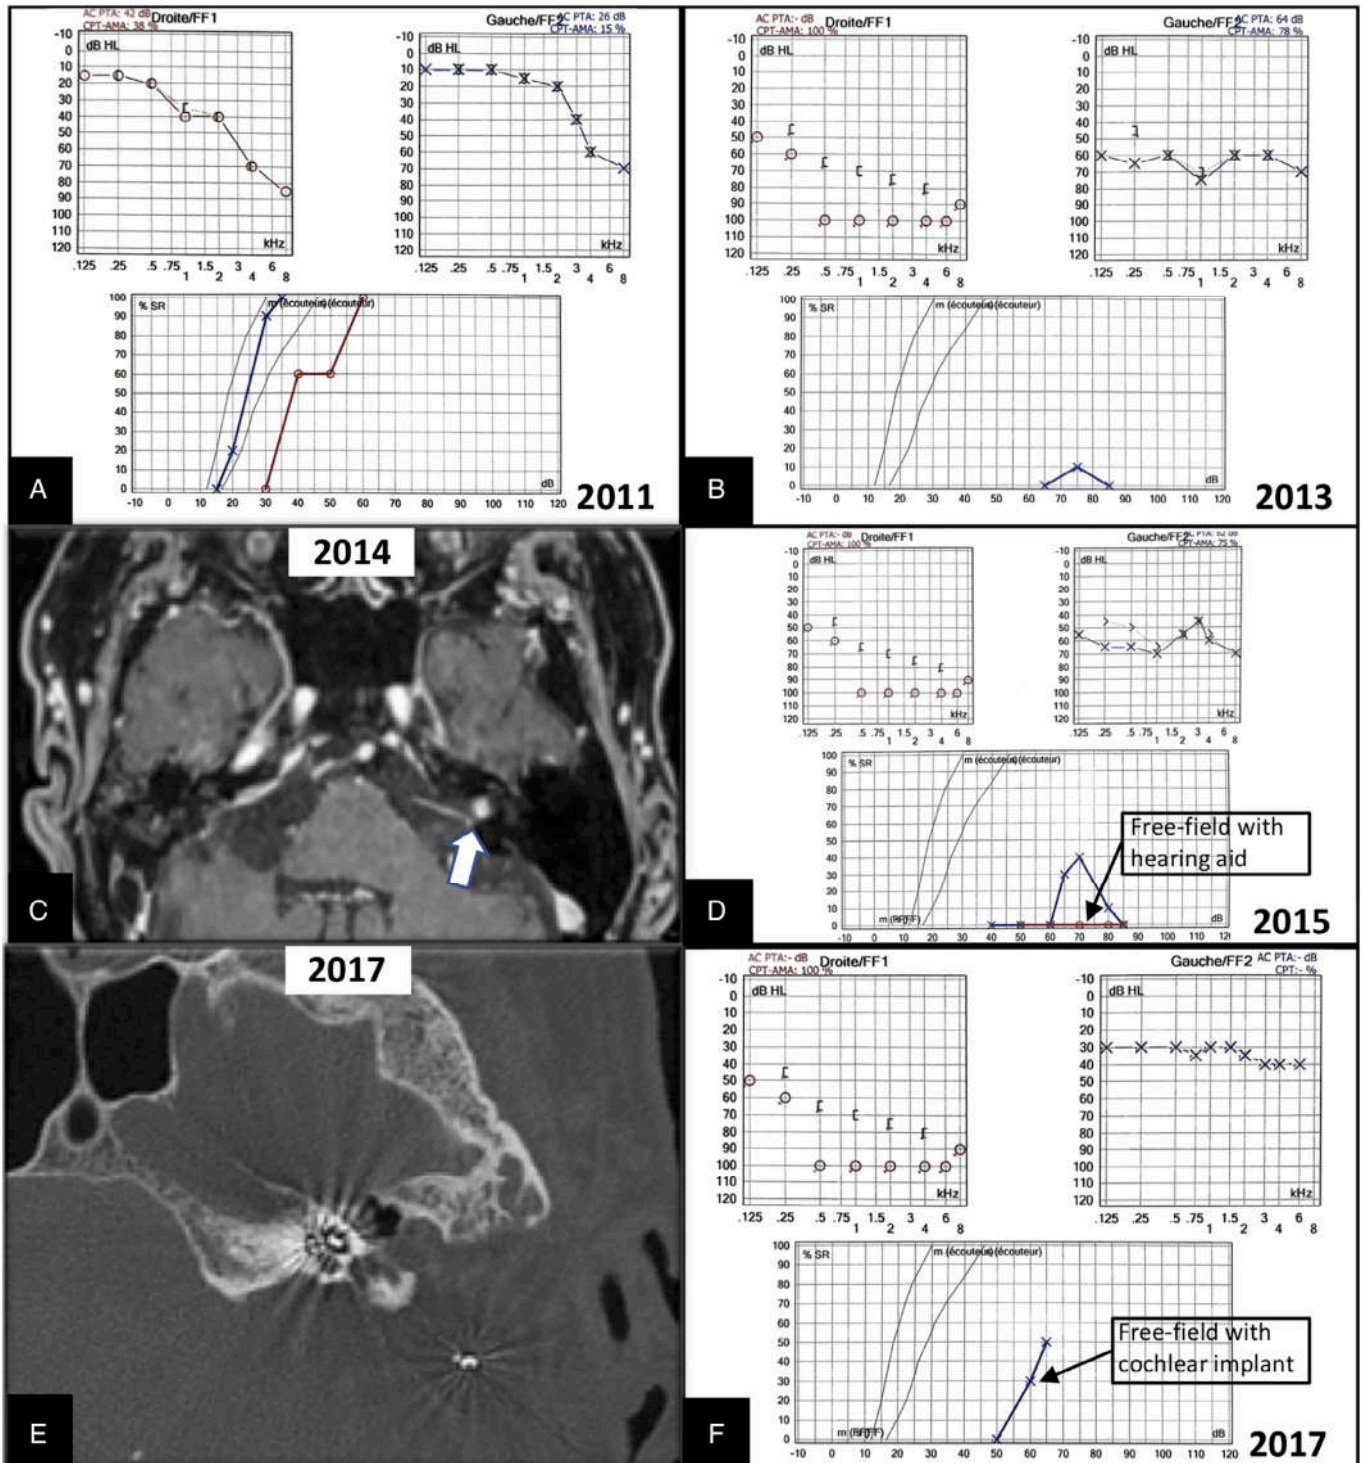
Case 4. (A) Audiogram showing the hearing loss before right vestibular schwannoma removal through a translabyrinthine approach. (B–D) Audiograms showing sudden left sensorineural hearing loss (SNHL) 2 years later (B) with partial recovery after intravenous steroid therapy and no benefit of hearing aid (D). (C) Postoperative axial T1-weighted gadolinium-enhanced magnetic resonance imaging showing evolution of a contralateral left side vestibular schwannoma (VS) (white arrow) revealed by sudden SNHL. (E) Postoperative computed tomography (CT) scan of the patient after removal of the left-sided VS through a translabyrinthine approach and insertion of a cochlear implant at the same side. (F) Patient's moderate left cochlear implant performance 1 year after implantation. [Color figure can be viewed in the online issue, which is available at [www.laryngoscope.com](http://www.laryngoscope.com).]
